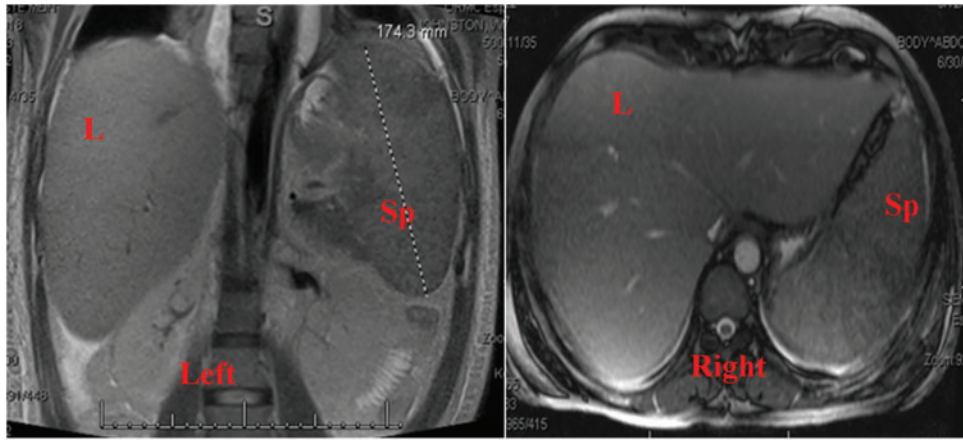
Coronal (left) and transverse (right) MRI of the abdomen and pelvis revealed hepatosplenomegaly, moderate splenomegaly with possible splenic infarcts, general pericholecystic fluid, and gallbladder wall thickening. L: liver, Sp: spleen.
